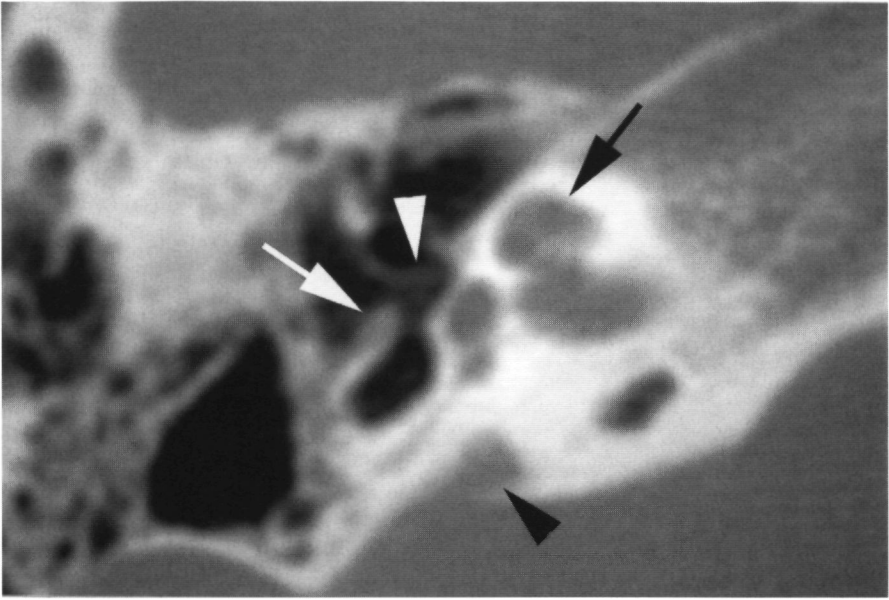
Axial computed tomography image at the level of the right pyramidal eminence obtained from patient III-4 showing hypoplasia/dysplasia of pyramidal eminence and stapes. The pyramidal eminence is hypoplastic and appears as a flat structure (white arrow). The muscle inside the pyramidal eminence and the capitulum of the stapes. The stapes is hypodysplastic, and only a small anterior crus of the stapes can be seen (white arrowhead). The apical and second turn of the cochlea can hardly be separated (black arrow) and the modiolus is hypoplastic. The large vestibular aqueduct is seen (black arrowhead).
